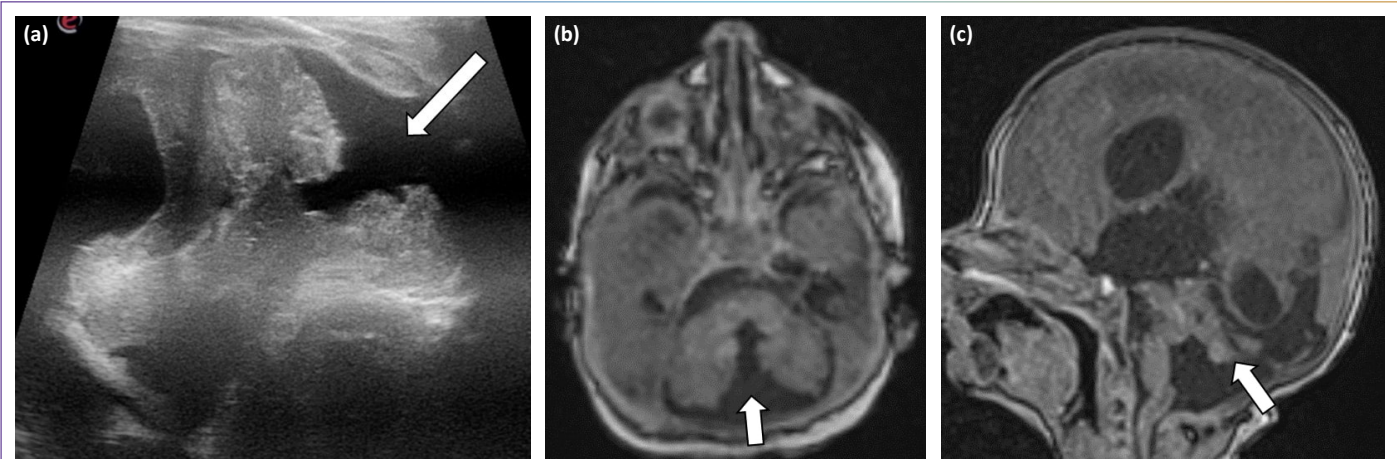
In a 38-week-old newborn, the cerebellar vermis cannot be clearly identified in the MF-CUS examination (a). In the MRI examination of the patient, it is observed that the vermis is severely hypoplastic and angled towards the cranial (b, arrow). In this patient with a diagnosis of Walker Warburg syndrome, a kink in the brainstem was noted (c).
